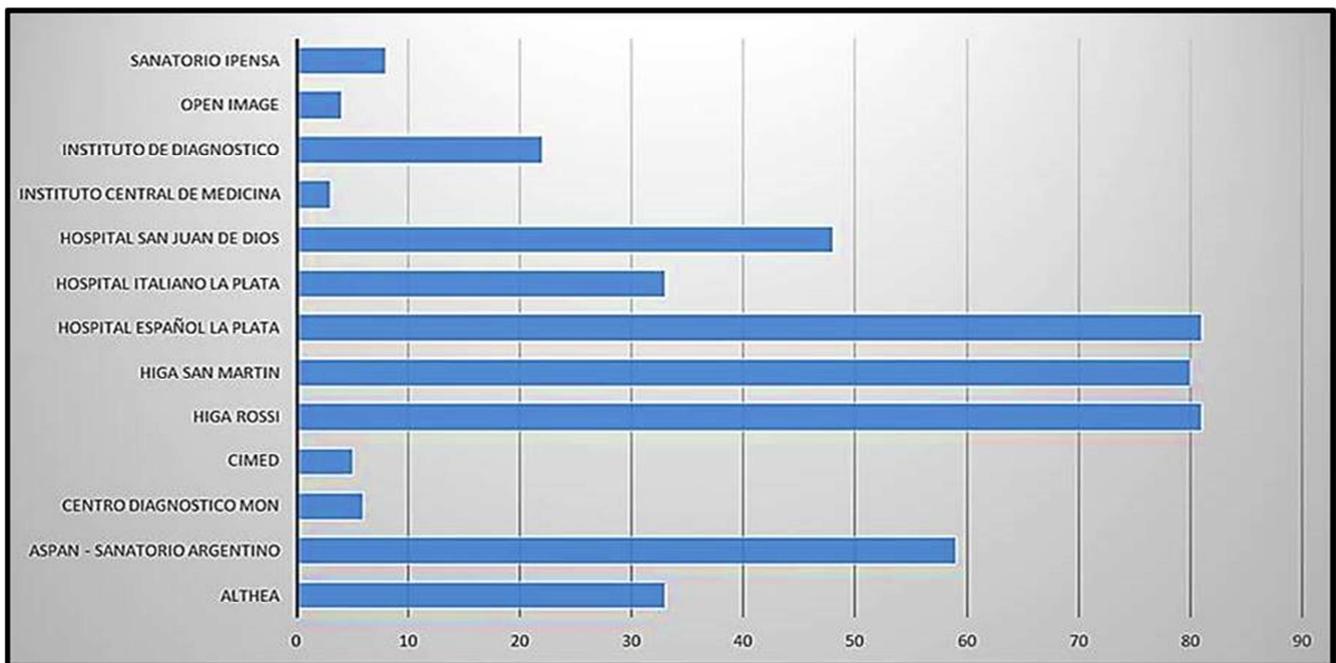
Number of CT scans provided by each center for the study.
